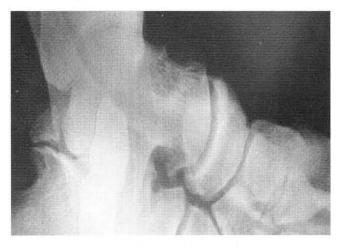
Preoperative radiograph of hypertrophic os trigonum
